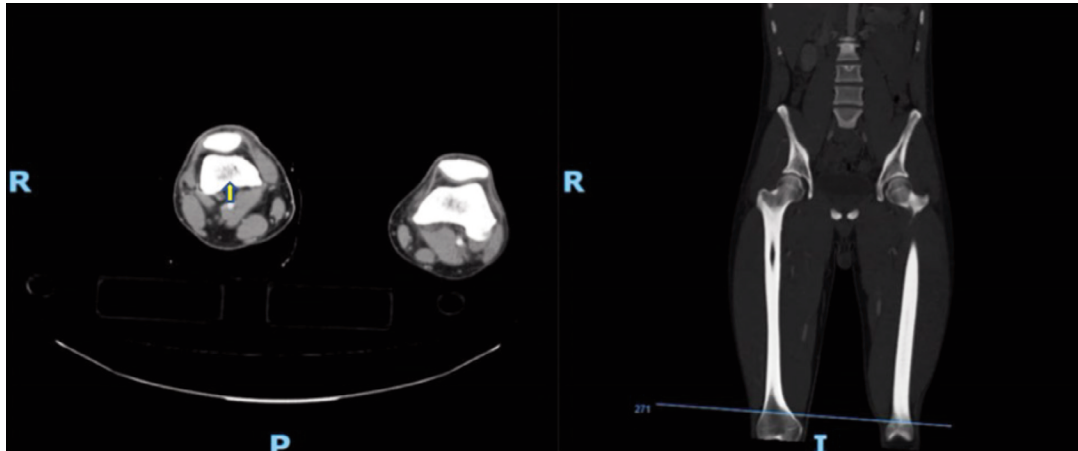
Axial and coronal CT (computed tomography) cuts showing how the shortest distance from the outer cortex of the femur at the level of the adductor tubercle to the superficial femoral and profunda femoris artery is measured (yellow arrow: distance from femur to profunda femoris artery, red arrow: distance from femur to superficial femoral artery).
